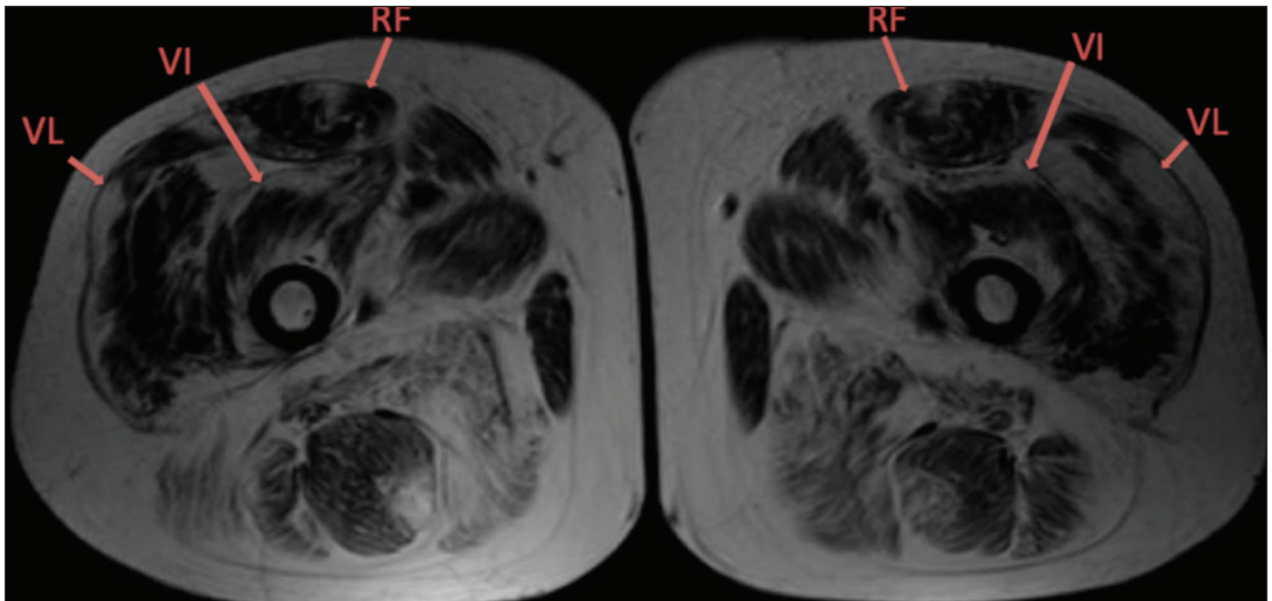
Lower limb muscle MRI, axial thigh level: concentric fatty infiltration in vastus lateralis (VL) and intermedius (VI) and an anterocentral infiltration in rectus femoris (RF), corresponding to a “central shadow” or a “U-shaped” infiltration.
